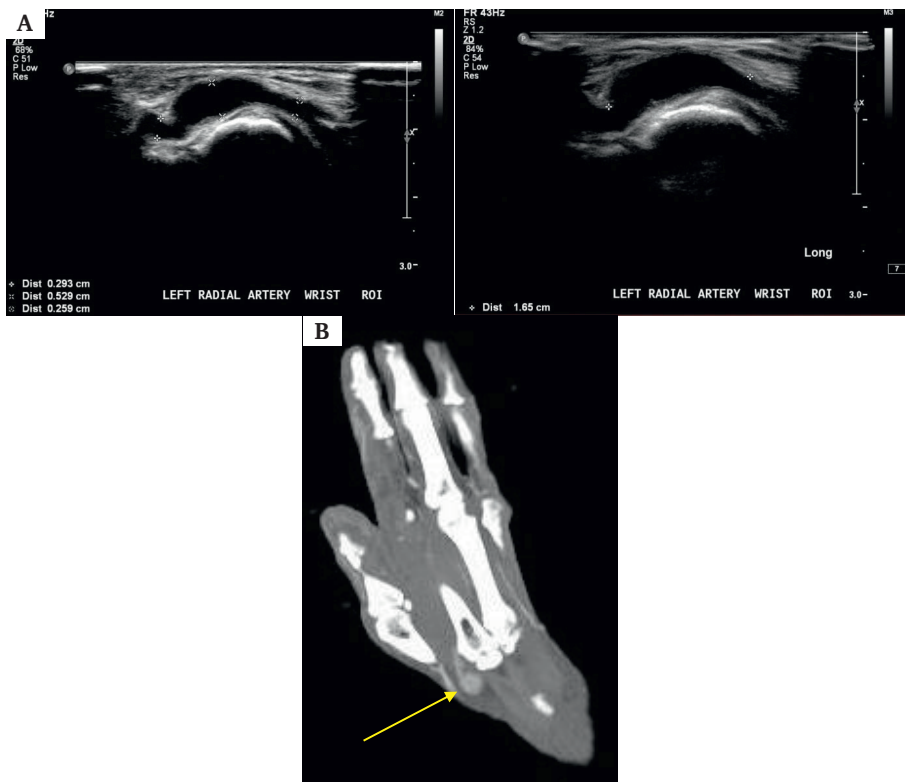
(A) Duplex ultrasound and (B) computed tomography angiogram showing the distal radial artery aneurysm in the area of the anatomical snuffbox.
